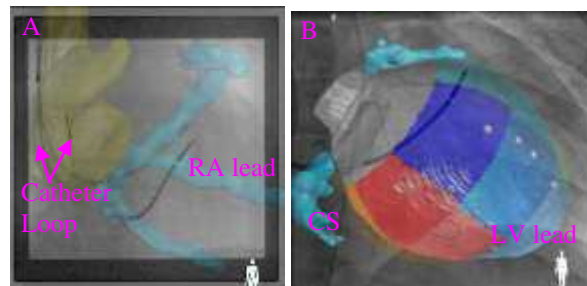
(A) Using a catheter loop to register the 3D anatomical model with the X-ray fluoroscopic images. (B) Using the 16 segment AHA model to show latest activating region. Grey spheres are the 3D LV lead positions (current and previous), which have been projected to the LV surface.
